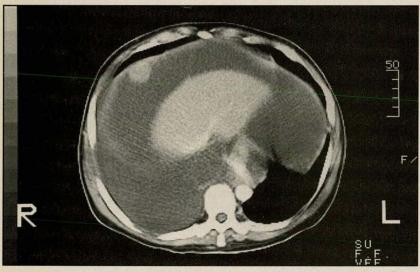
Contrast-enhanced CT image of the upper part of abdomen in this same patient shows 2×2 -cm metastatic nodule attached to peritoneal surface of right side of diaphragm. Note large pleural effusion on right.
